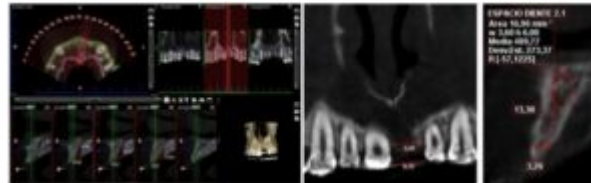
Cone Beam of the upper jaw
